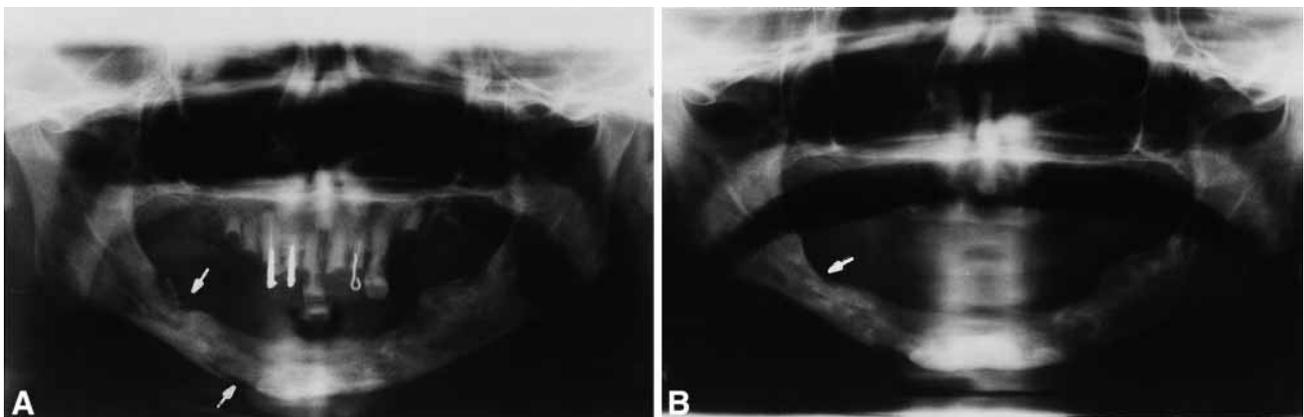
A. Panoramic radiograph showing ORN involving the inferior border (white arrow) and the right body (lower white arrow) of the mandible, which developed after salvage surgery 4 months after radiation therapy. B. Panoramic radiograph of healing mandible following sequestrectomy and HBO. Note: white arrow points to healed bone with remucosalized defect over vital bone.
